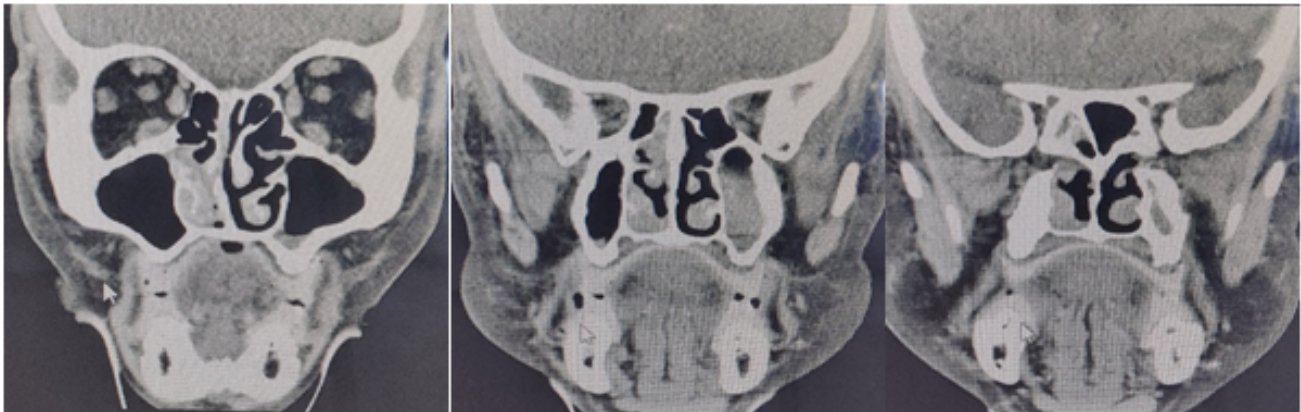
CT scan PNS coronal cuts: showing mucosal thickening in maxillary, ethmoid and sphenoid sinuses with heterogenous densities s/o fungal sinusitis.
